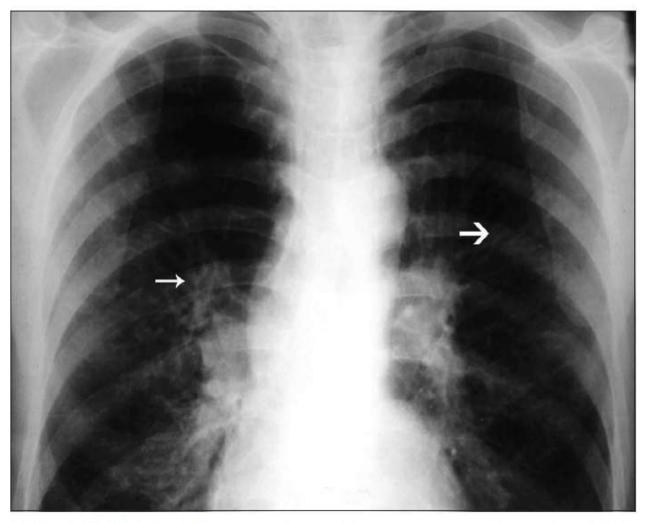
Chest radiograph shows the presence of tram-line (thick arrow) and parallel-line (thin arrow) shadows
